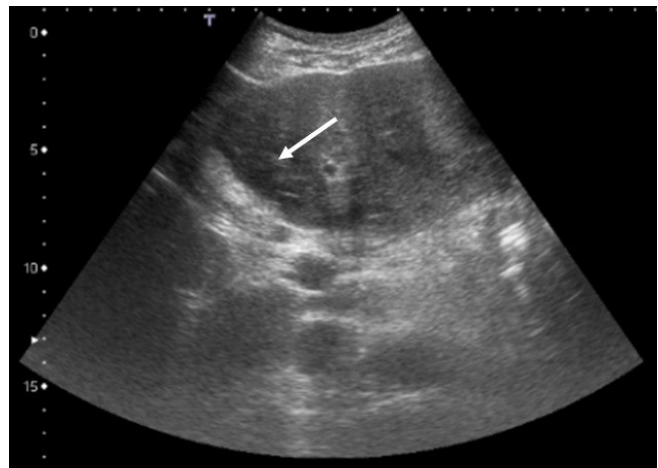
Grayscale ultrasound of the liver demonstrates multiple liver lesions (arrow).
